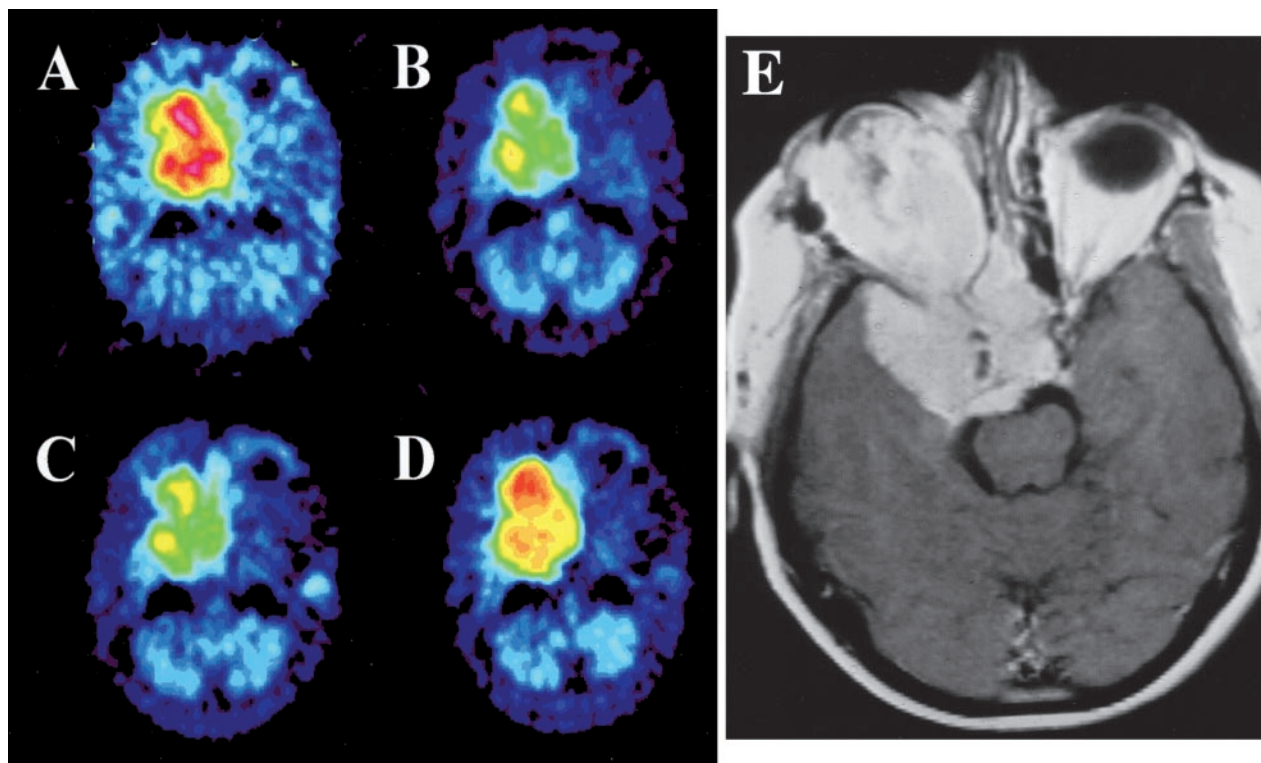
PET analysis for patient 6. A, before treatment. B, decreased methionine uptake after treatment with IFN-α for 42 months and 24 days. C, decreased methionine uptake before withdrawal of IFN-α treatment after 54 months and 20 days. D, increased methionine uptake 11 months and 10 days after withdrawal of treatment. E, MR image in axial projection demonstrating the large skull base meningioma with tumor growth extending into the orbit.
